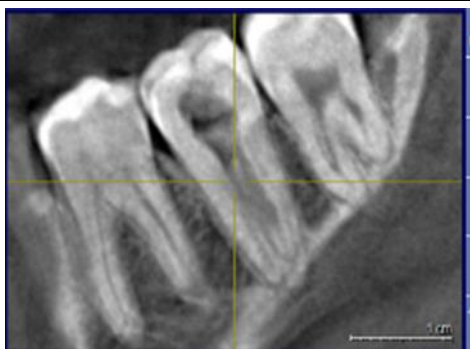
CBCT evaluation – mesio oblique view
